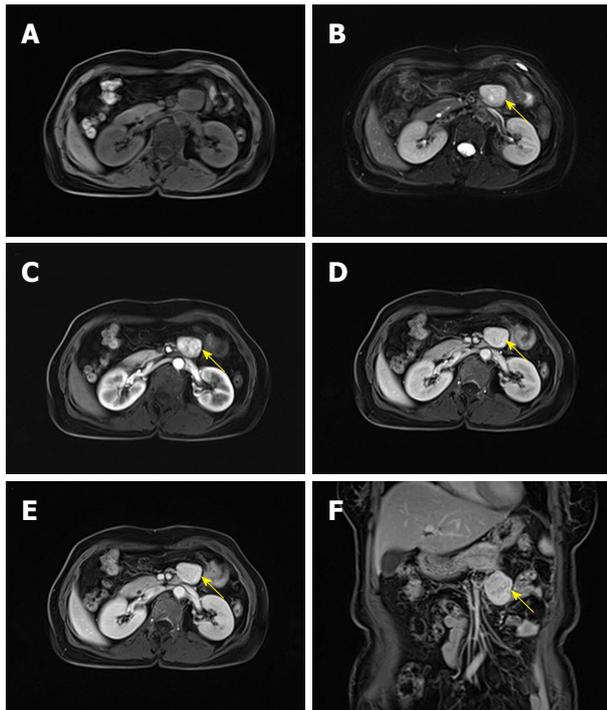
Magnetic resonance imaging of the lesion (yellow arrow) in Case 2. A: Transverse T1-weighted fat-suppression sequence; B: Transverse T2-weighted fat-suppression sequence; C: Transverse T1-weighted fat-suppression sequence (arterial phase); D: Transverse T1-weighted fat-suppression sequence (venous phase); E: Transverse T1-weighted fat-suppression sequence (delayed phase); F: Coronal T1-weighted fat-suppression sequence (delayed phase).
